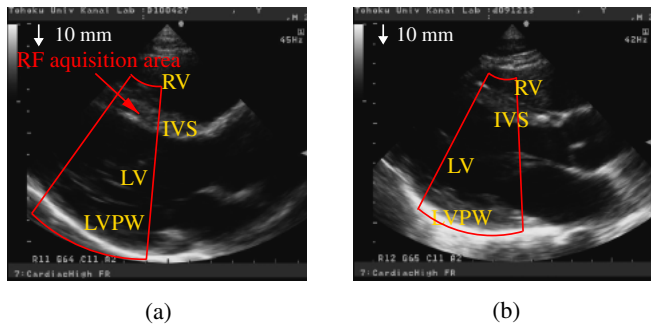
(Color online) Cross-sectional images of the left ventricle in longitudinal axis view obtained by conventional echocardiography for subjects (a) A and (b) B. The regions surrounded by a red line show acquisition areas of RF data.
